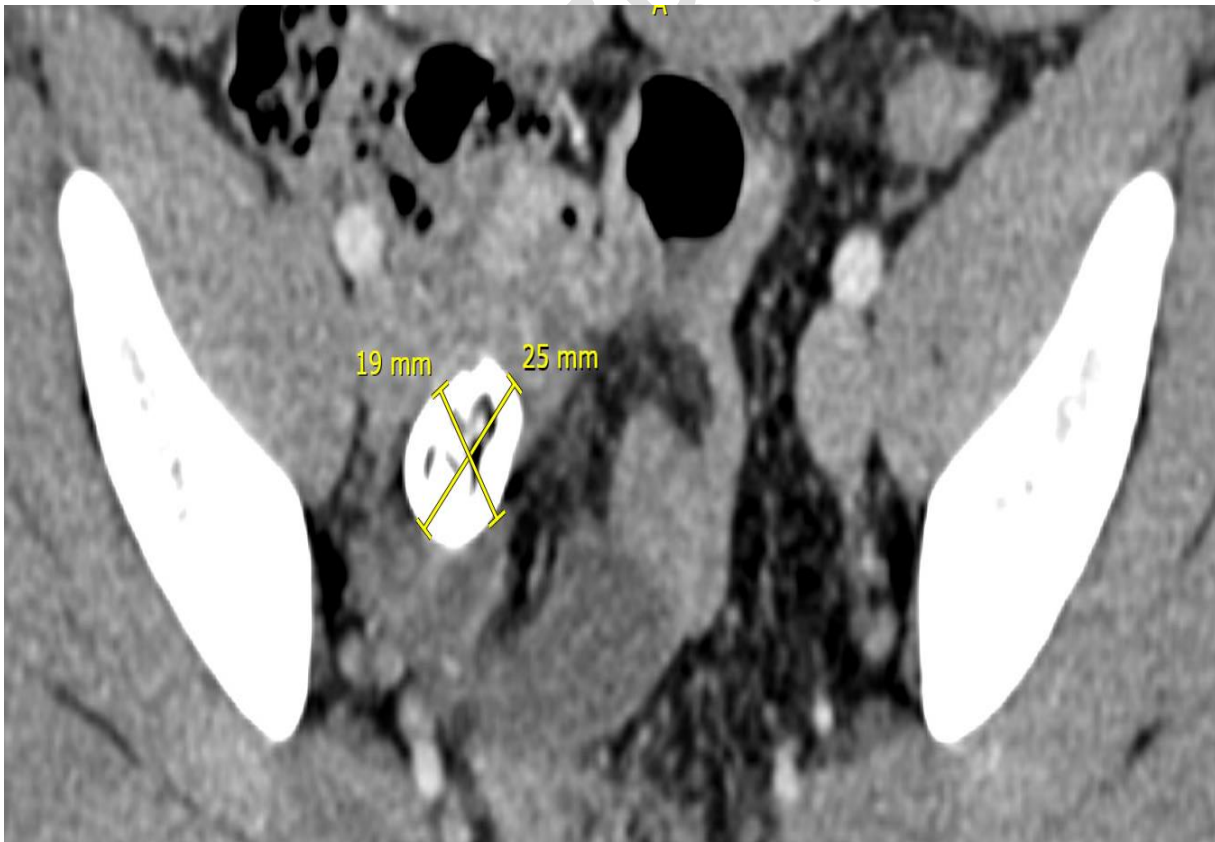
the CT of the abdomen.
